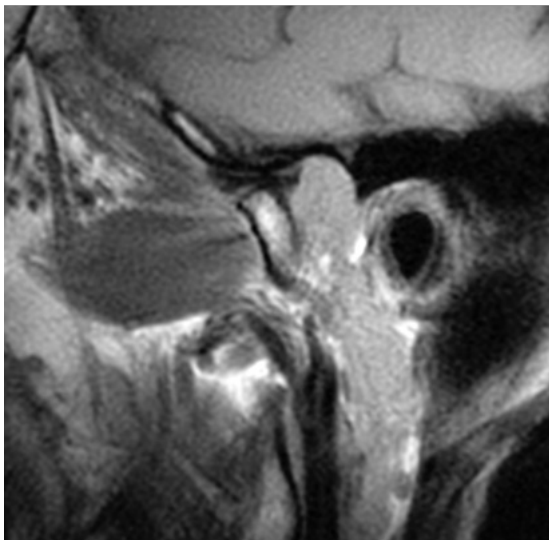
MRI TMJ right open mouth. Correct interposition expires.
